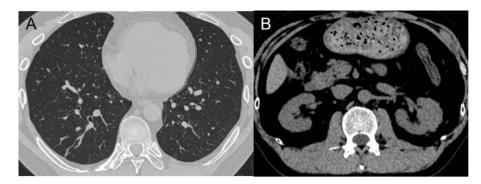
Computed tomography-guided percutaneous lung and kidney biopsy was then performed. The results indicated infiltration of acute and chronic inflammatory cells, hyperplasia of fiber and granulation tissue, which were rather nonspecific except for granulomatous inflammatory features. Otolaryngoscopy examination proved to be negative. Further laboratory examinations showed serum c-ANCA and serum PR3-ANCA tests were positive with c-ANCA titer equal to 1:10 (normal reference range: negative) and PR3-ANCA 8.6U/mL (normal reference range: less than 1.0 U/mL), respectively. Granulomatosis with polyangiitis (GPA) was highly suspected, subsequently, the patient was treated with methyloprednisolone and cyclophosphamide. After eight cycles, the patient had significant clinical improvement and radiographic remission with reduction of pulmonary nodules and renal mass (A, B), which finally led to a diagnosis of GPA.
